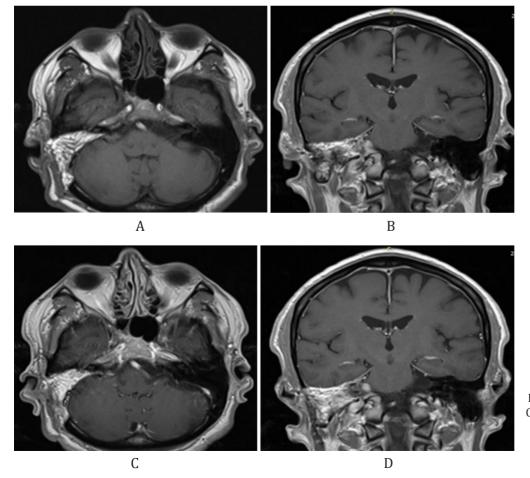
MRI imaging with visualization: CPA 3 months postoperatively A – axial plane; B – coronal plane; CPA 1 year postoperatively C – axial plane; D – coronal plane.
